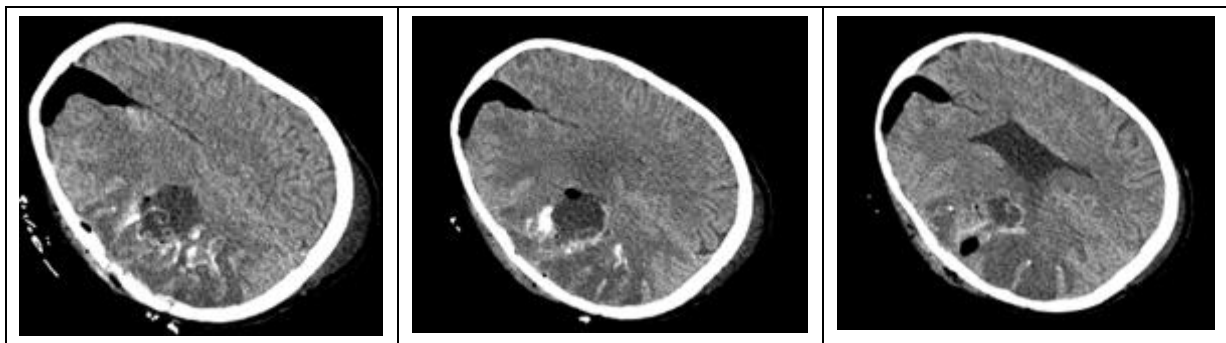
Early postoperative brain CT scan demonstrating the tumor resection cavity with satisfactory extent of resection, associated with postoperative hemorrhagic changes within the surgical bed
